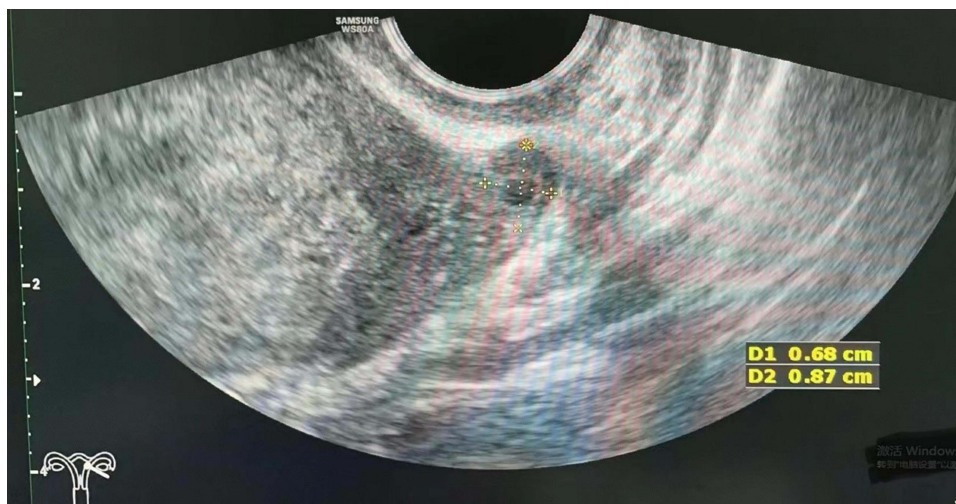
The ultrasound imaging demonstrates a mass at the residual segment of the left fallopian tube (isthmus) consistent with an ectopic pregnancy.
